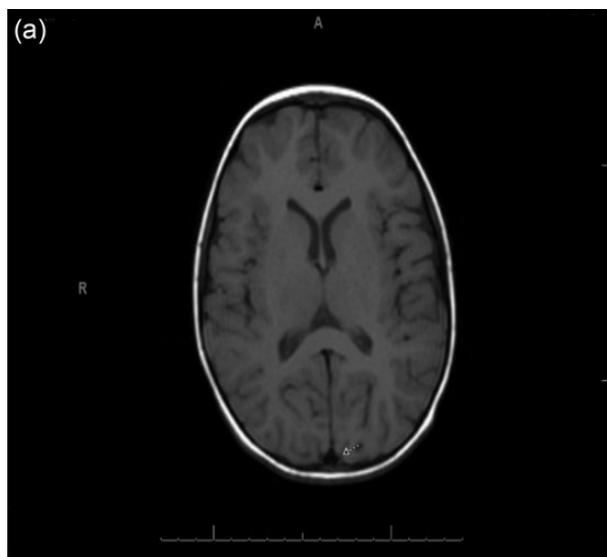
(a and b) MRI brain after treatment showing complete recanalization of the superior sagittal and left transverse venous sinuses.
